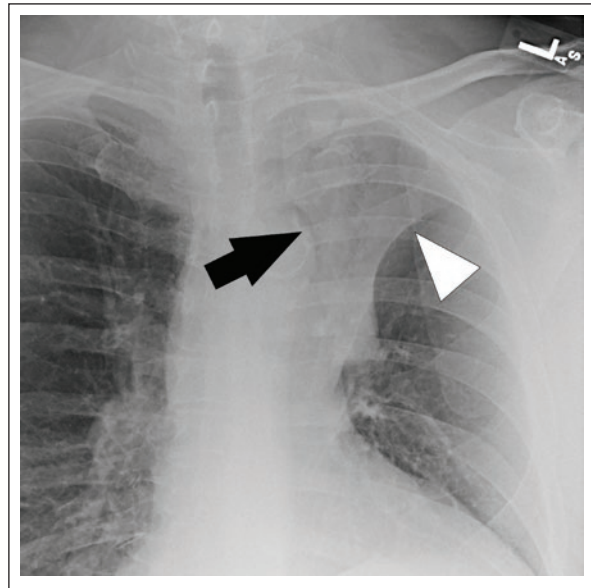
Patient with cervical aortic arch without the cervicothoracic sign. A: frontal chest radiograph shows abnormal convexity along the left superior mediastinum with well-defined inferior and superior borders (arrow), indicating that this mass is entirely within the chest and does not extend into the neck. B: nonenhanced chest CT shows cervical aortic arch (arrow). This example is provided to contrast and clarify the cervicothoracic sign.
